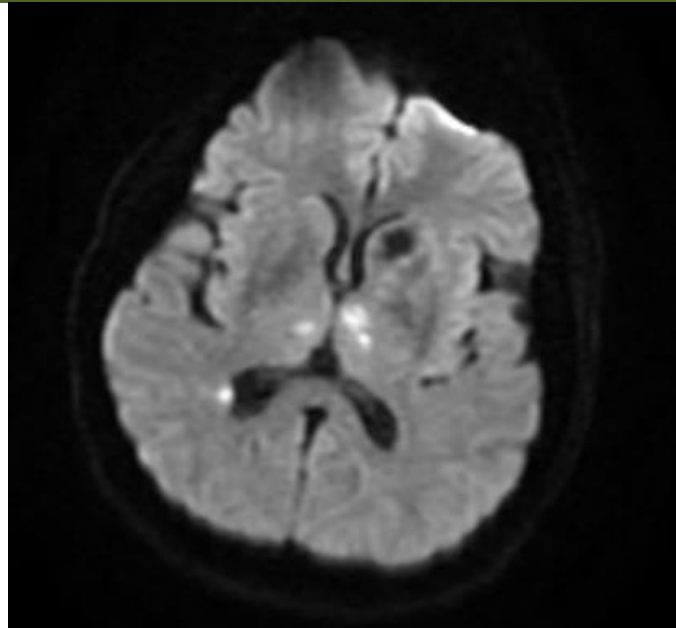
Axial diffusion-weighted MRI demonstrating multiple acute ischemic lesions involving the deep territory of the left middle cerebral artery (MCA) and bilateral thalamic territories supplied by the posterior cerebral arteries (PCA), consistent with an embolic stroke pattern affecting both anterior and posterior circulation
